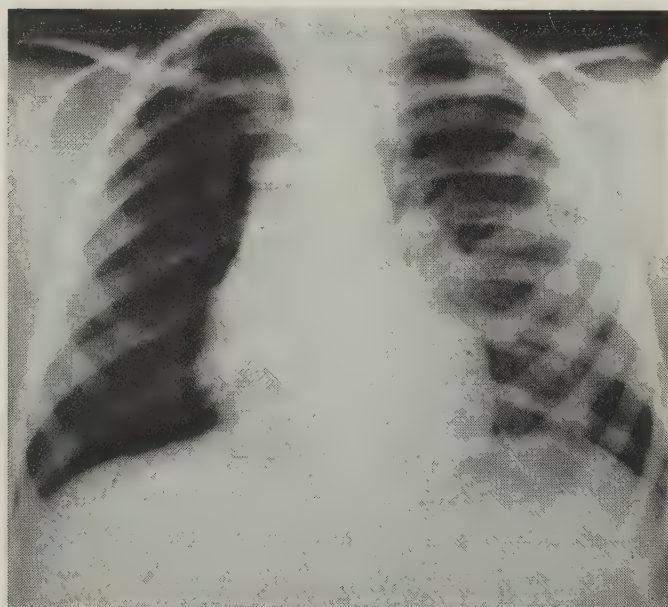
Shown is radiograph of the chest of J. H. subsequent to therapy.
